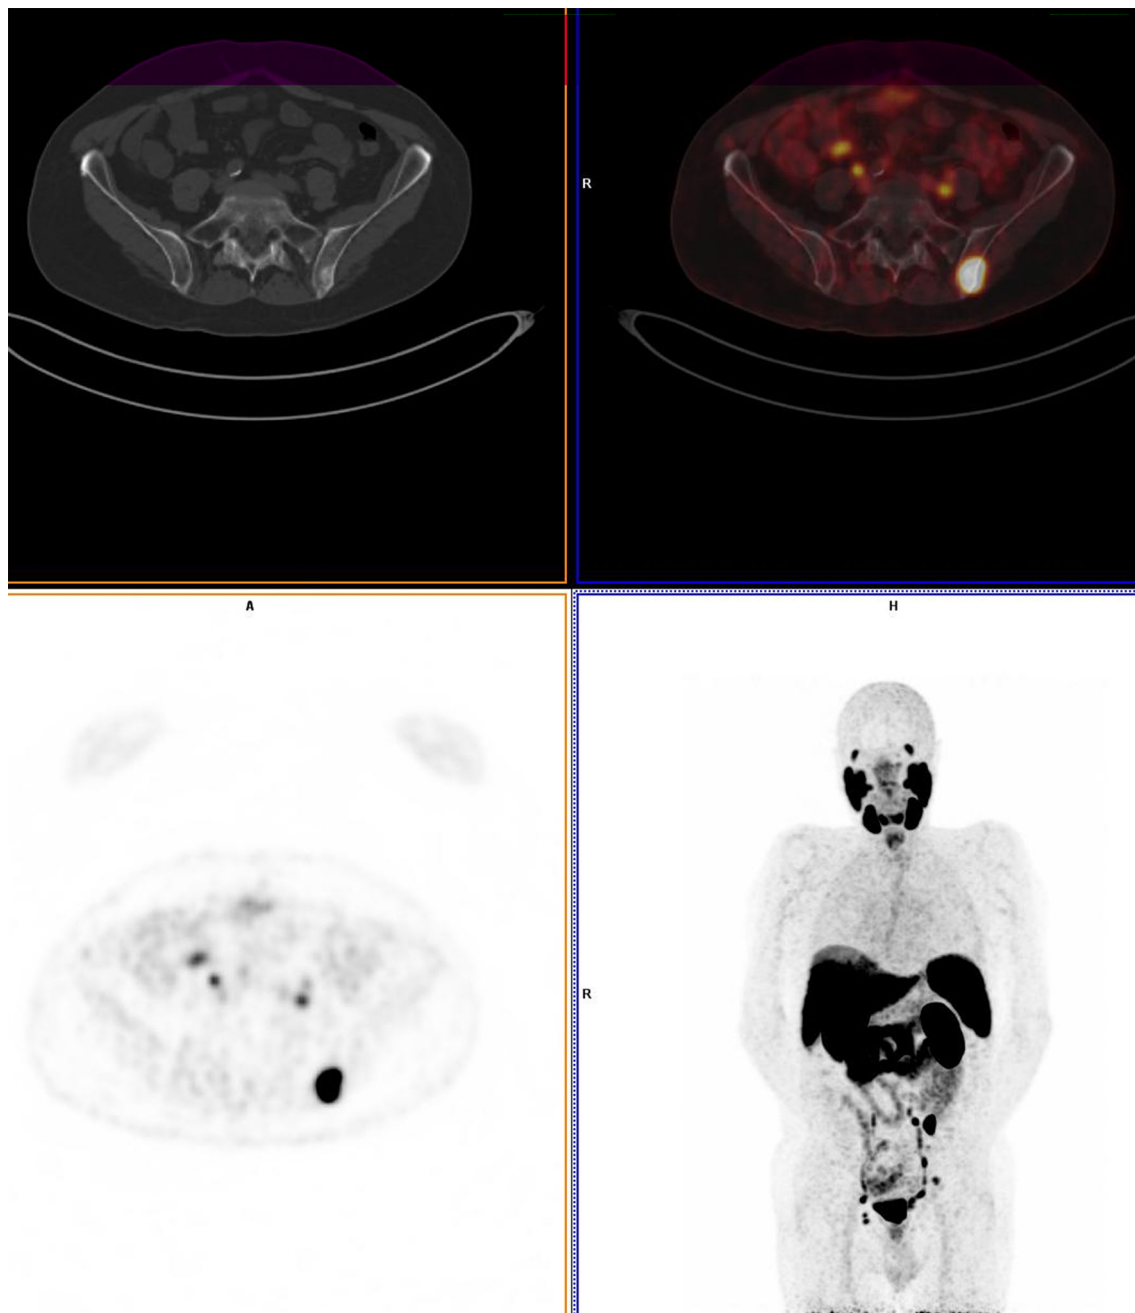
CT images of a 73-year-old man, with a PSA value of 4.7 ng/ml, showing a sclerotic lesion in the posterior left iliac bone, with an intense ⁶⁸Ga-PSMA uptake in PET-CT (SUVmax = 20.9)
